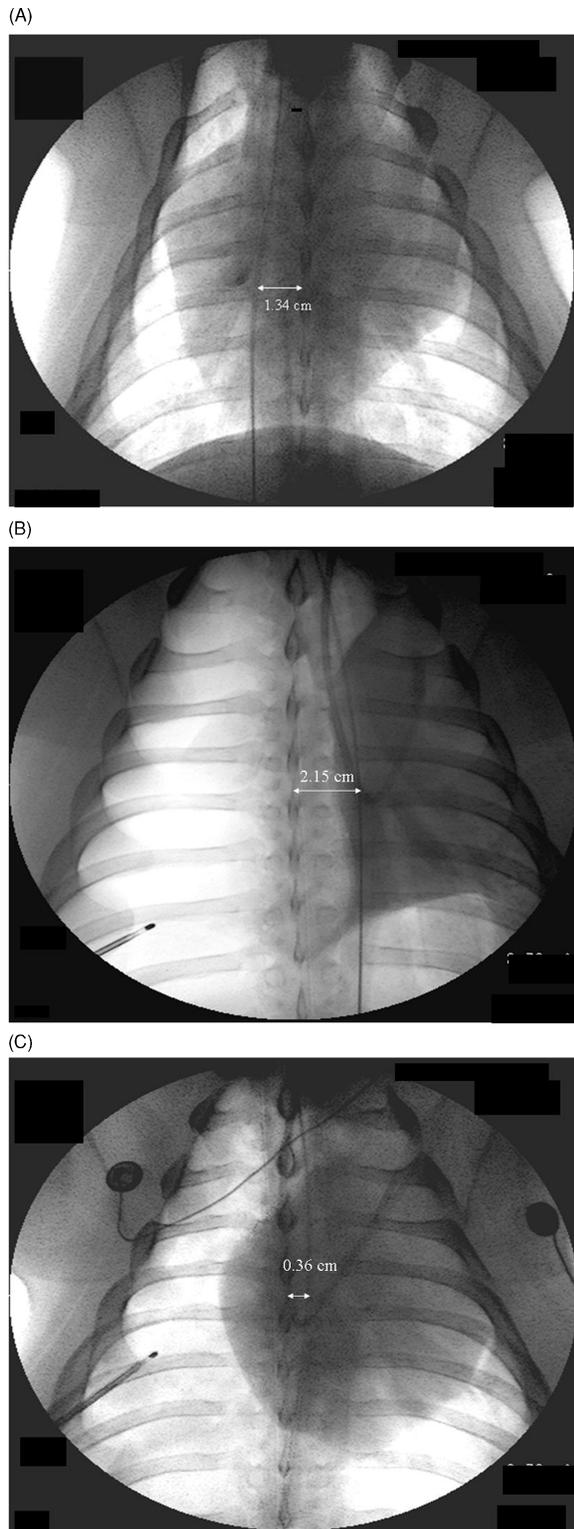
Chest radiographs demonstrating creation and treatment of tension hemopneumothorax. A: Preinsufflation baseline: J-wire in the inferior vena cava 1.34 cm to the right of the spinous processes. B: Insufflation resulted in a mediastinal shift of 2.15 cm to the left of the spinous processes, resulting in a total shift of 3.49 cm from baseline. C: Partial return of mediastinum immediately after treatment with a needle catheter.
